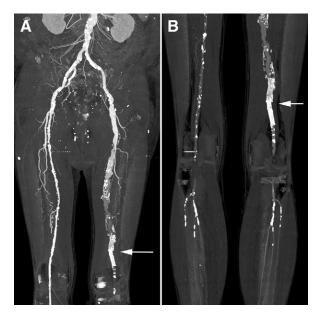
Computed tomography angiogram (A) of the abdomen, pelvis, and lower extremities reveals aneurysmal degeneration of the left superficial femoral artery (SFA) status post common femoral endarterectomy, superficial femoral remote endarterectomy, and popliteal stenting (*arrows*). Note the preserved runoff only seen on delayed imaging (B).
